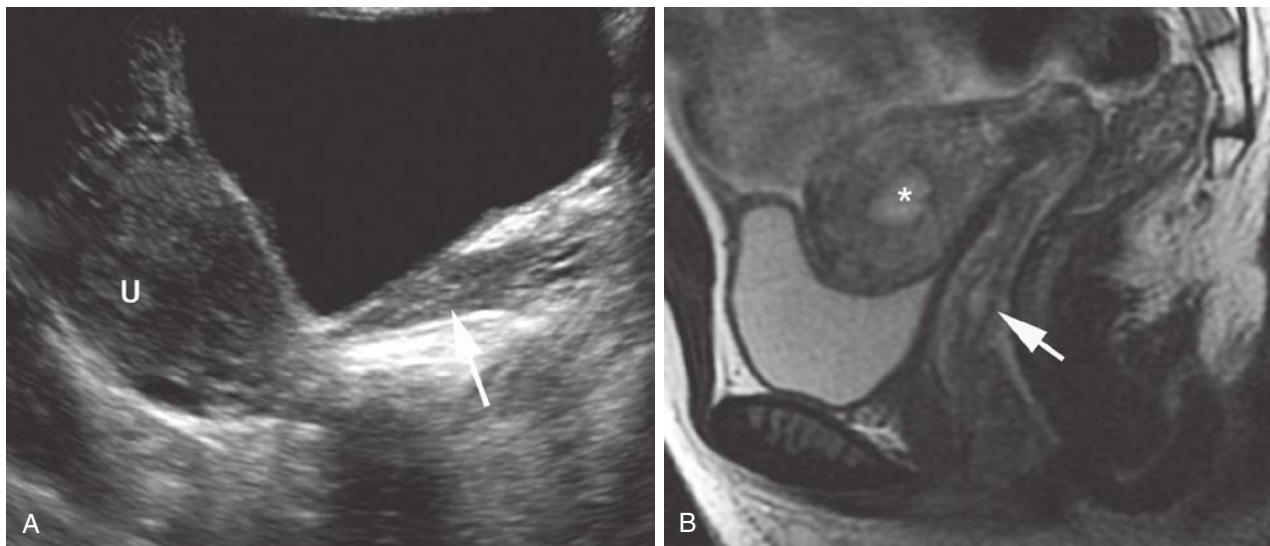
Agenesia of the cervix and upper vagina in a 16-year-old girl with pelvic pain. A, Sagittal ultrasound image reveals a uterus (U) without evidence of a cervix or upper vagina. The lower vagina is present (arrow). B, Sagittal T2-weighted magnetic resonance image confirms absence of a normal cervix and upper vagina with no communication between the endometrial cavity (asterisk) and the midvaginal canal (arrow).
